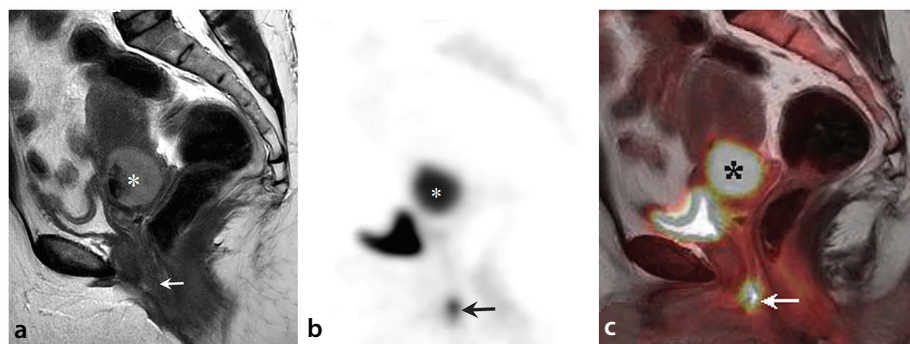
Vaginal condyloma acuminatum. The sagittal T2-weighted magnetic resonance image (MRI) (a) shows no visible vaginal abnormality (arrow) in a patient with endometrial cancer invading cervical stroma (asterisk). The sagittal positron emission tomography (PET) (b) and sagittal fused PET/MRI (c) show FDG uptake in the vagina (arrow), mimicking metastasis. However, the hospital records indicate the presence of vaginal condyloma acuminatum, which are known to exhibit FDG uptake. FDG, fluorodeoxyglucose.
